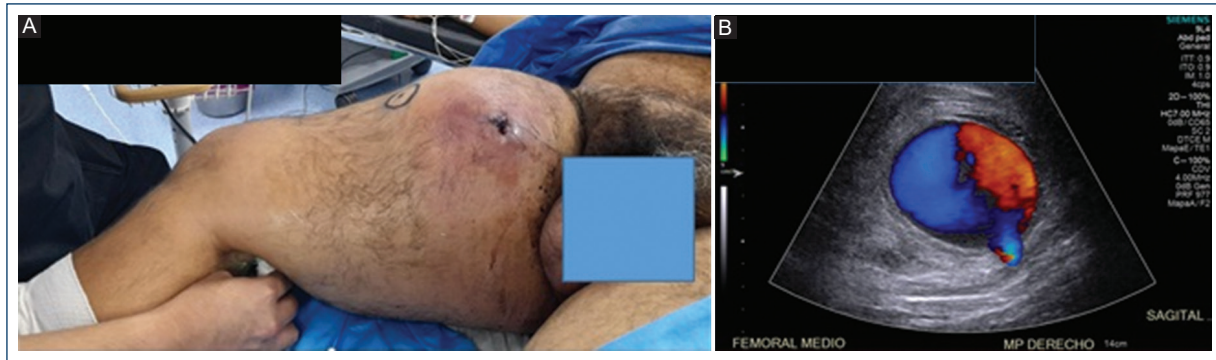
A: pseudoaneurysm of the femoral artery due to a gunshot wound. B: color duplex Doppler ultrasound of the femoral pseudoaneurysm.
